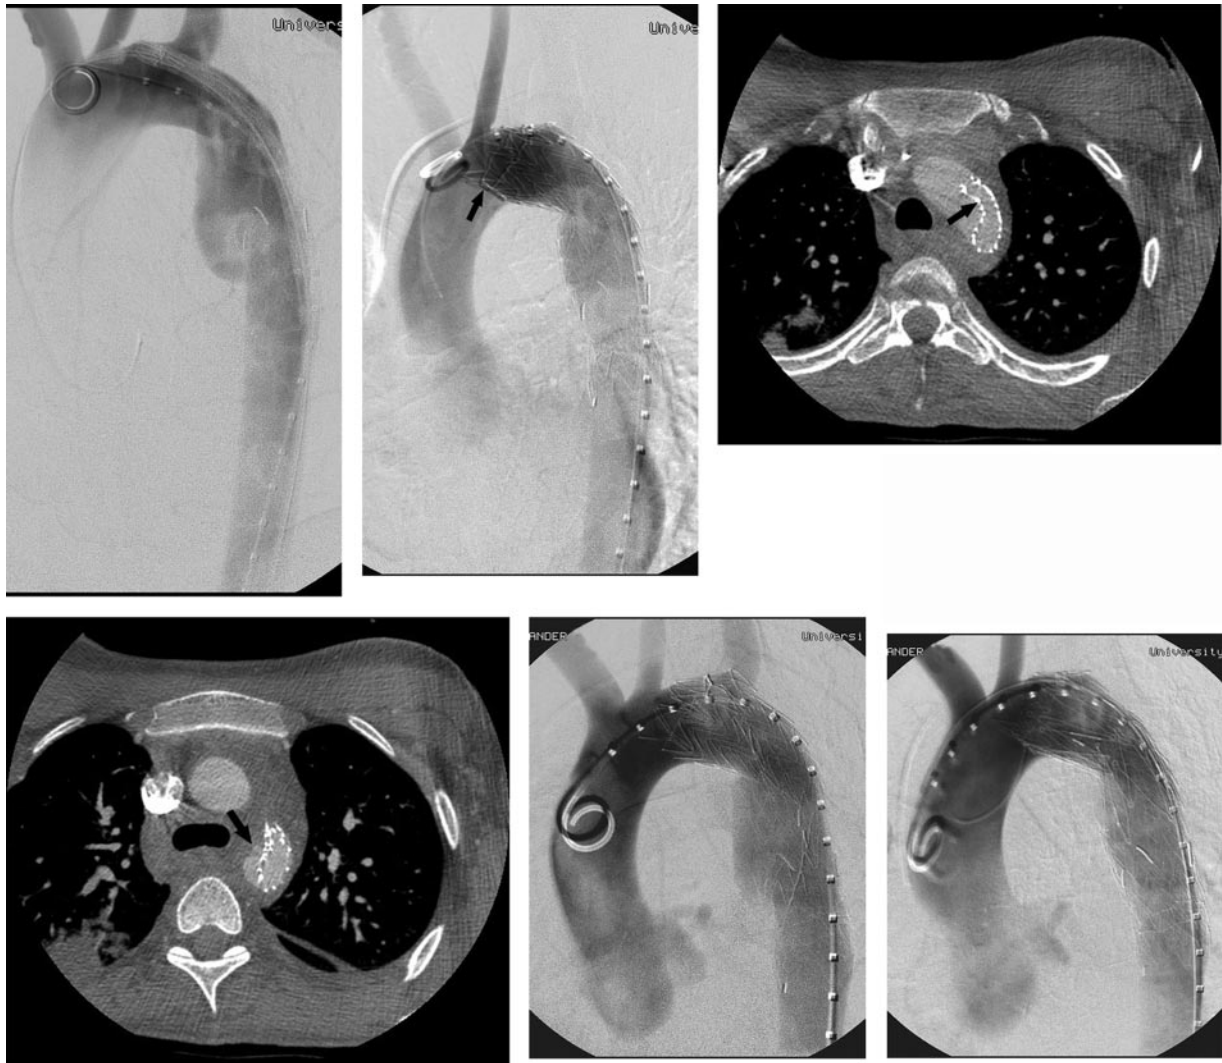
Beaking of thoracic endoprosthesis. Top left, Baseline thoracic aortography in left anterior oblique projection shows a traumatic pseudoaneurysm several cm distal to the left subclavian artery. Aortic diameter proximal to the left subclavian artery measured 23 mm, and distal to the pseudoaneurysm measured 21 mm. Top middle, Thoracic aortography following deployment of a 23-mm-diameter cuff distally and a 26 mm × 10 cm thoracic endograft proximally. Considerable beaking of the leading edge of the endograft is present (arrow), with lack of conformity of the proximal endograft with the tight inner curve of the aortic arch. The left subclavian artery was covered intentionally to exclude the pseudoaneurysm, which does not opacify. Top right, CT examination of the chest 2 days following implantation of the endografts shows collapse of the leading edge of the endograft (arrow). Bottom left, On a CT slice several centimeters more caudally, the endograft remains collapsed posterolaterally, resulting in revascularization of the pseudoaneurysm (arrow). Bottom middle, Thoracic aortography confirms posterior collapse of the endograft and reopening of the pseudoaneurysm. Bottom right, After placement of a self-expanding z-stent in the proximal endograft and reballoon of the endoprosthesis, the endograft has been reexpanded and the pseudoaneurysm was once again excluded. Although beaking persists, the endograft has remained fully expanded and the pseudoaneurysm has remained excluded for 3 years of follow-up. CT indicates computed tomographic imaging.
